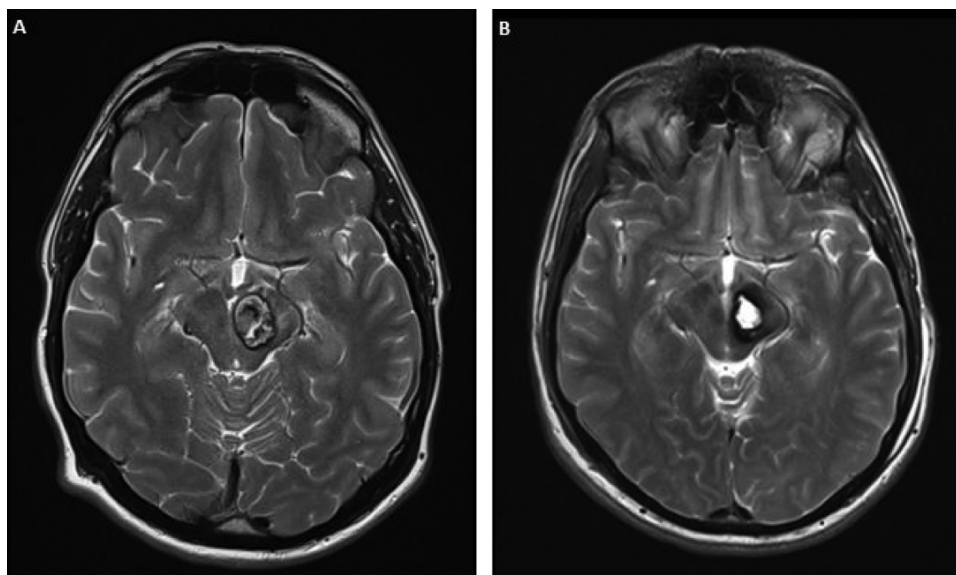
Patient 18: A. preoperative T2-weighted brain MRI showing the mesencephalic cavernoma with involvement of red nucleus and substantia nigra. B. Postoperative T2-weighted brain MRI showing the resection cavity undertaking the normal localization of the red nucleus.
